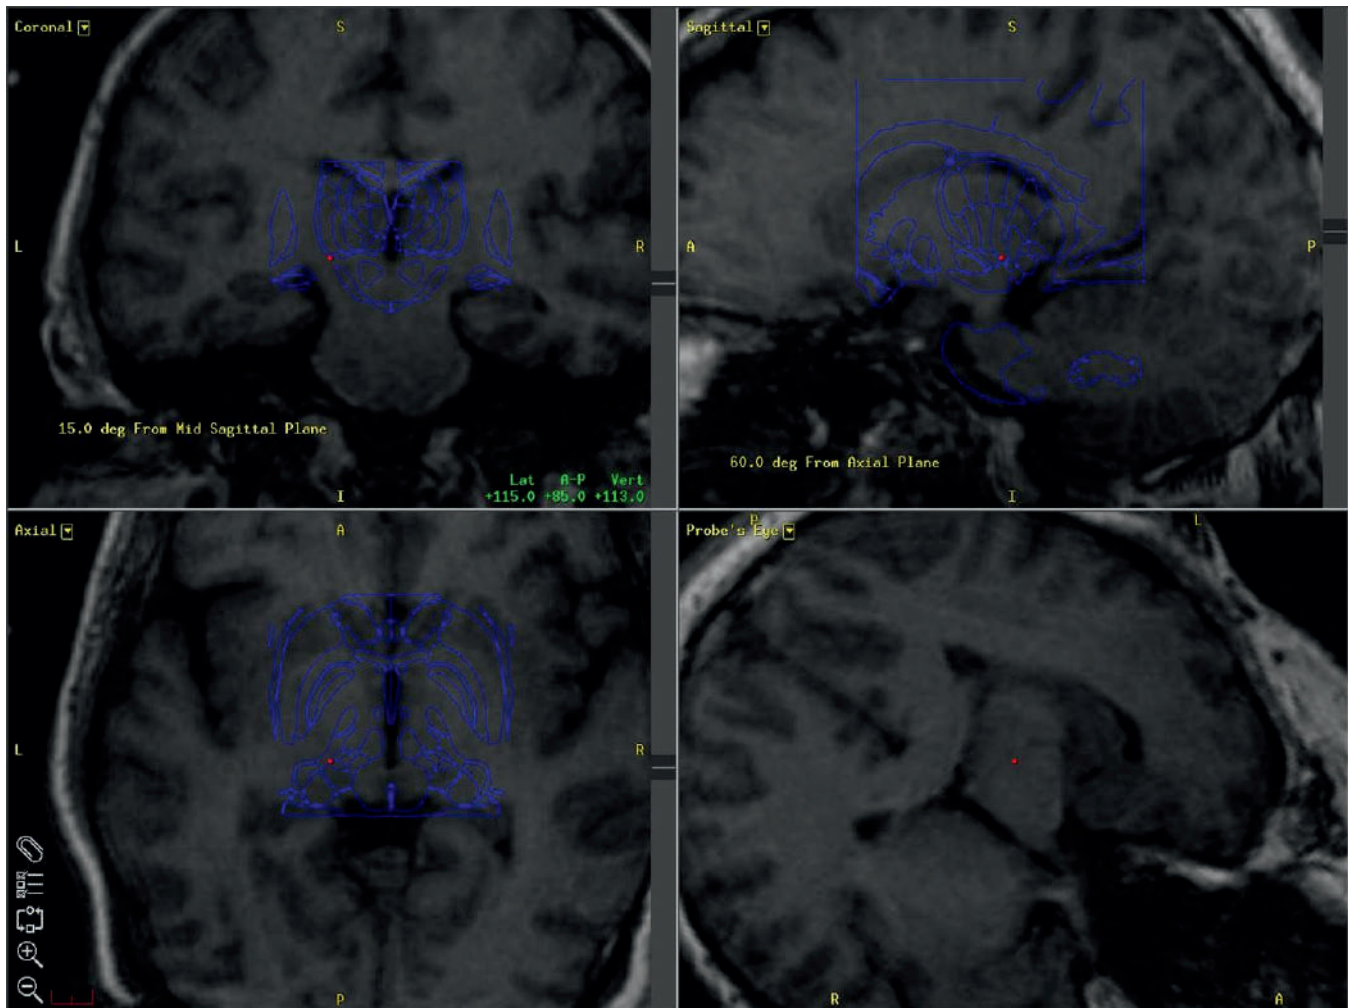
Anatomical brain maps for targeting. Planning station screenshot showing digitized Schaltenbrand and Wahren atlas overlay on preoperative patient MRI (magnetic resonance imaging) with Leksell frame on. This image shows an example of target selection for VC (ventral caudalis).
